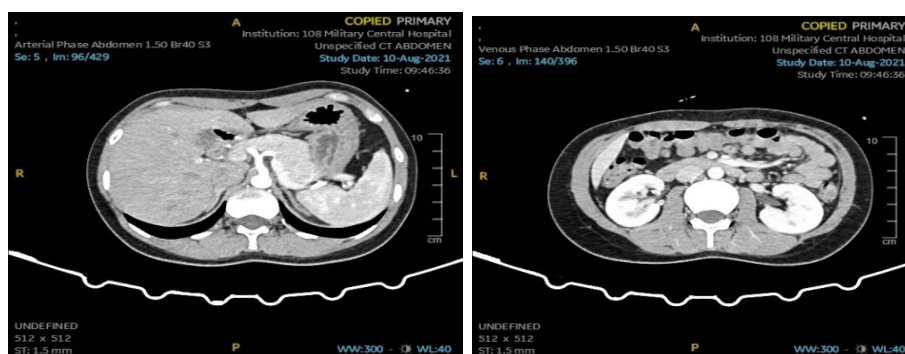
Abdominal computed tomography: It showed no obstruction of middle colic branch of superior mesenteric artery in the transaxial view, no obstruction of inferior mesenteric artery in the transaxial view.
